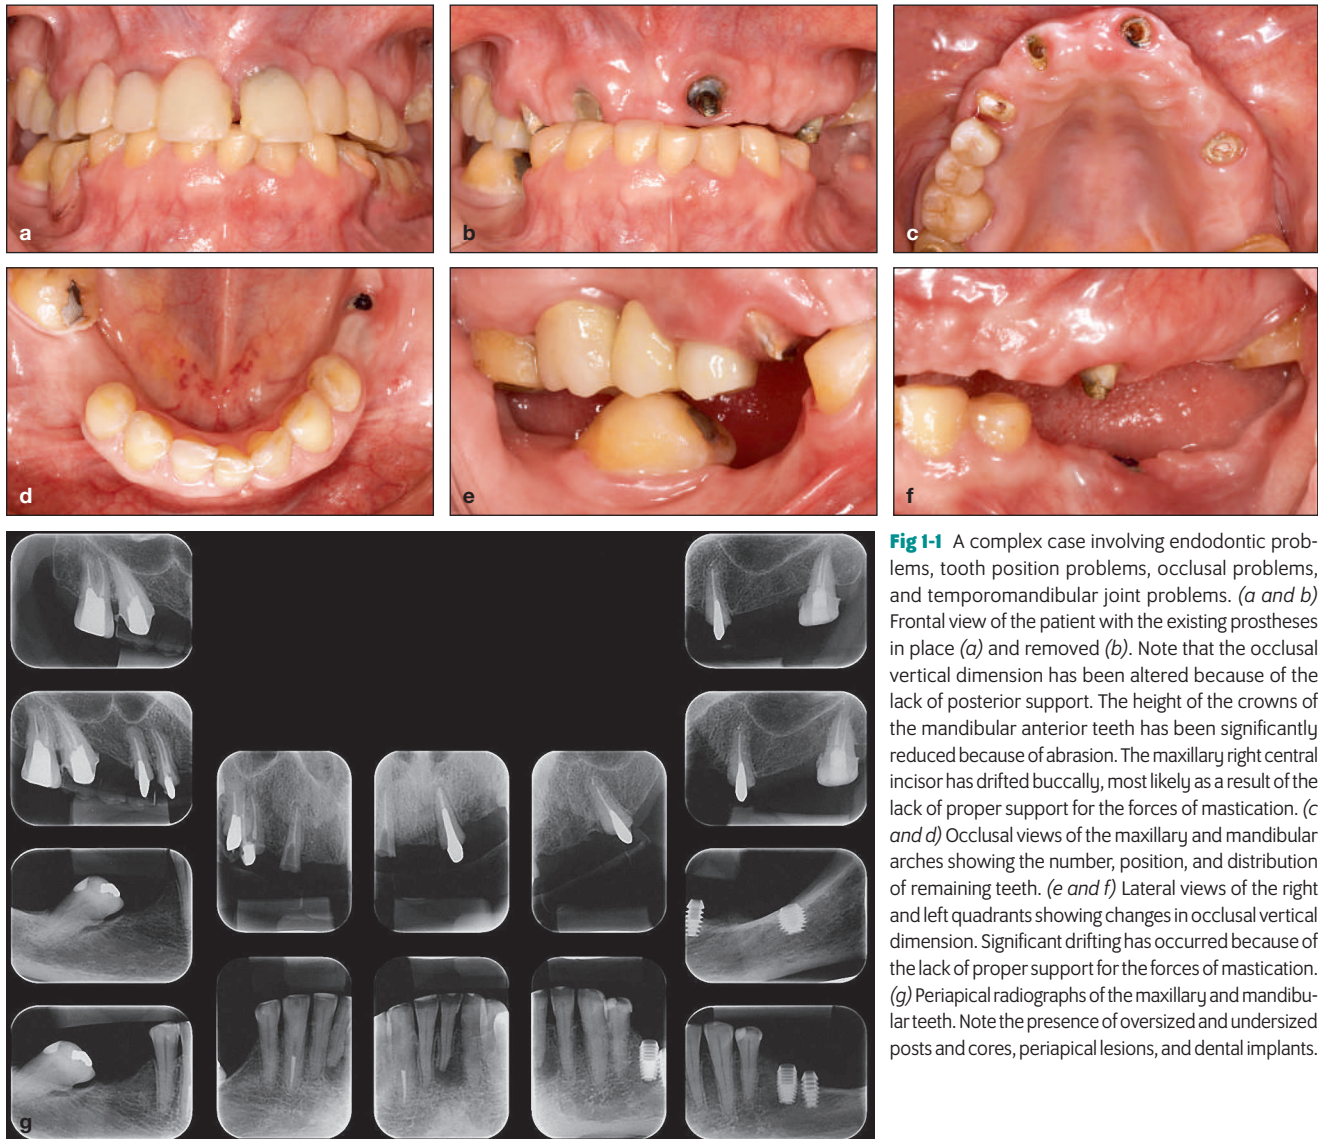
A complex case involving endodontic problems, tooth position problems, occlusal problems, and temporomandibular joint problems. (a and b) Frontal view of the patient with the existing prostheses in place (a) and removed (b). Note that the occlusal vertical dimension has been altered because of the lack of posterior support. The height of the crowns of the mandibular anterior teeth has been significantly reduced because of abrasion. The maxillary right central incisor has drifted buccally, most likely as a result of the lack of proper support for the forces of mastication. (c and d) Occlusal views of the maxillary and mandibular arches showing the number, position, and distribution of remaining teeth. (e and f) Lateral views of the right and left quadrants showing changes in occlusal vertical dimension. Significant drifting has occurred because of the lack of proper support for the forces of mastication. (g) Periapical radiographs of the maxillary and mandibular teeth. Note the presence of oversized and undersized posts and cores, periapical lesions, and dental implants.
